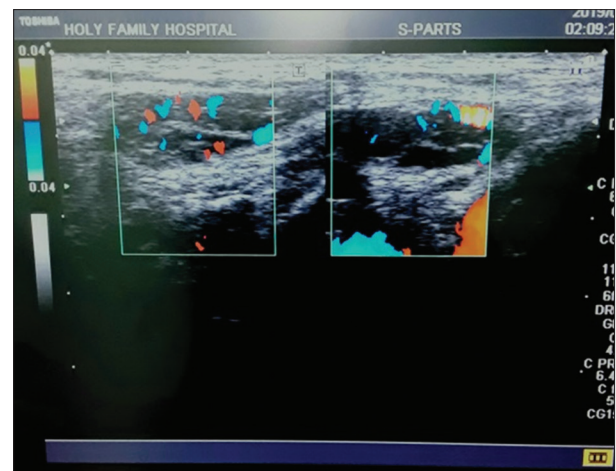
Color Doppler sonogram of inguinal masses
